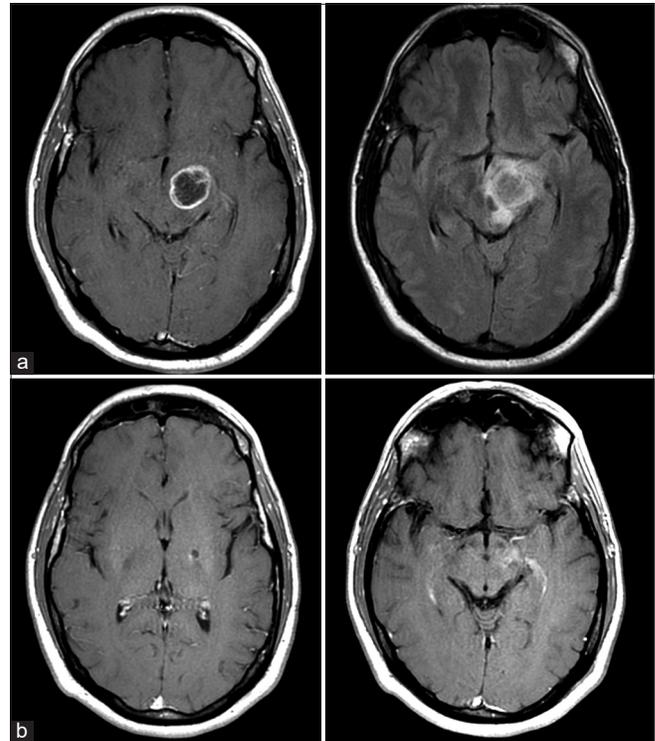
Pre and postoperative MRI. (a) Representative preoperative T1 contrast enhanced (left) and FLAIR (right) images. (b) Representative 46.9-month post-LITT T1 contrast enhanced (left) and FLAIR (right) images.
